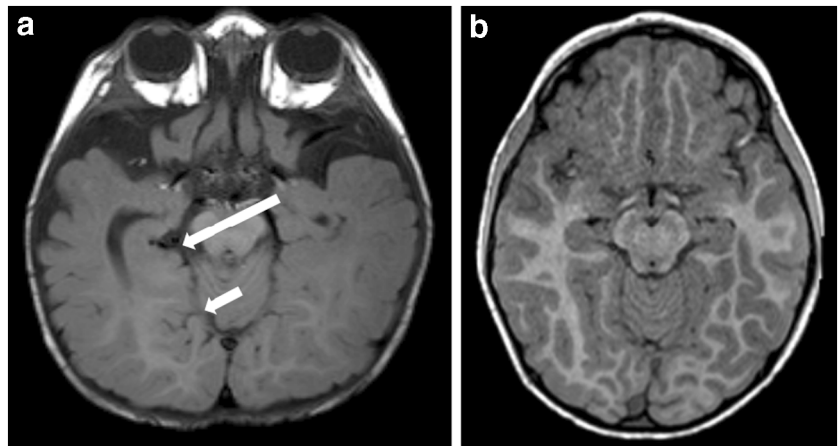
Oversulcation of mesial temporal lobe and calcar avis in the same 14-month-old boy as in Fig. 13. a Axial T1-weighted MR image (repetition time/echo time [TR/TE]: 500/15 ms) shows oversulcation of the mesial temporal lobe (*long arrow*) and extension of the oversulcation to the calcar avis (*short arrow*). b Axial T1-weighted MR image (TR/TE: 500/15 ms) of a normal child for comparison shows the normal sulcation pattern of the mesial temporal lobe and calcar avis
